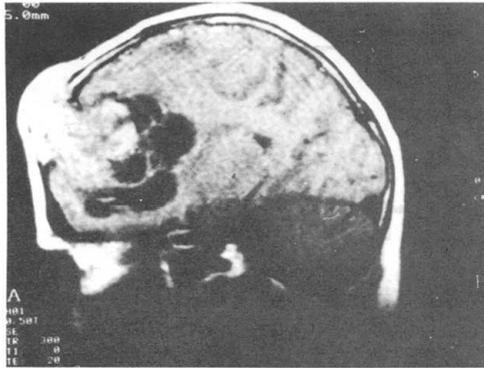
Parasagittal MRI (SE 300/20) showing a right frontal lobe mass that has both solid and cystic components. There is a dural thickening in the frontal region and the mass is extending extracranially.
